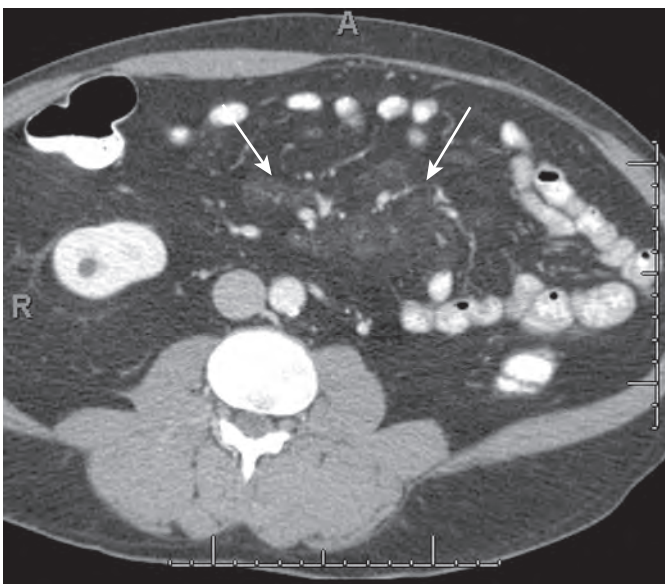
Sclerosing mesenteritis. Axial CT in a patient with a carcinoid tumor of the small bowel and incidental detection of haziness in the mesentery (arrows). This was proved to be sclerosing mesenteritis.
